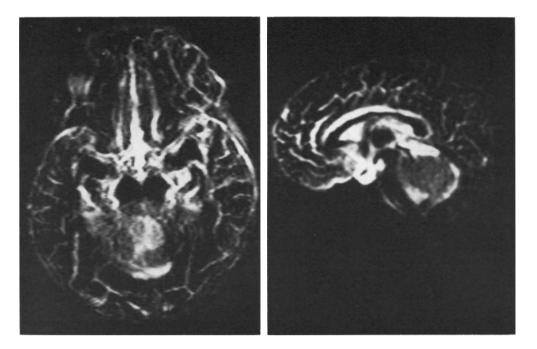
CT of a pseudocystic tumor within the fourth ventricle
